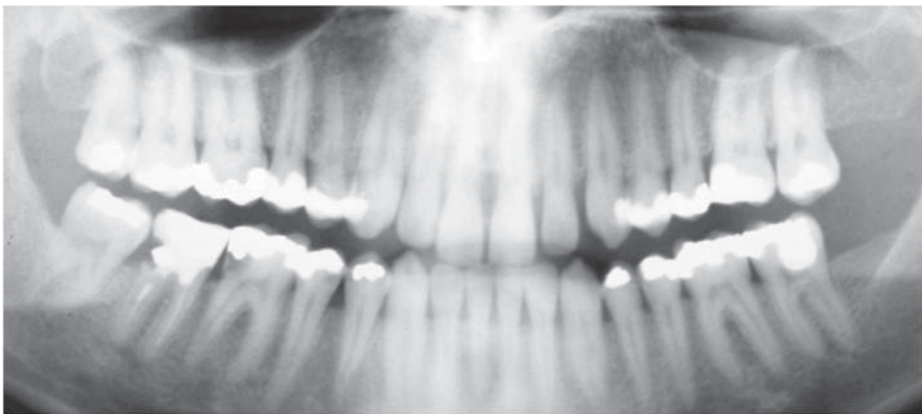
Orthopantomogram of an adult human showing the morphology of the permanent dentition, anatomical relationships, dental restorations and endodontic treatment
